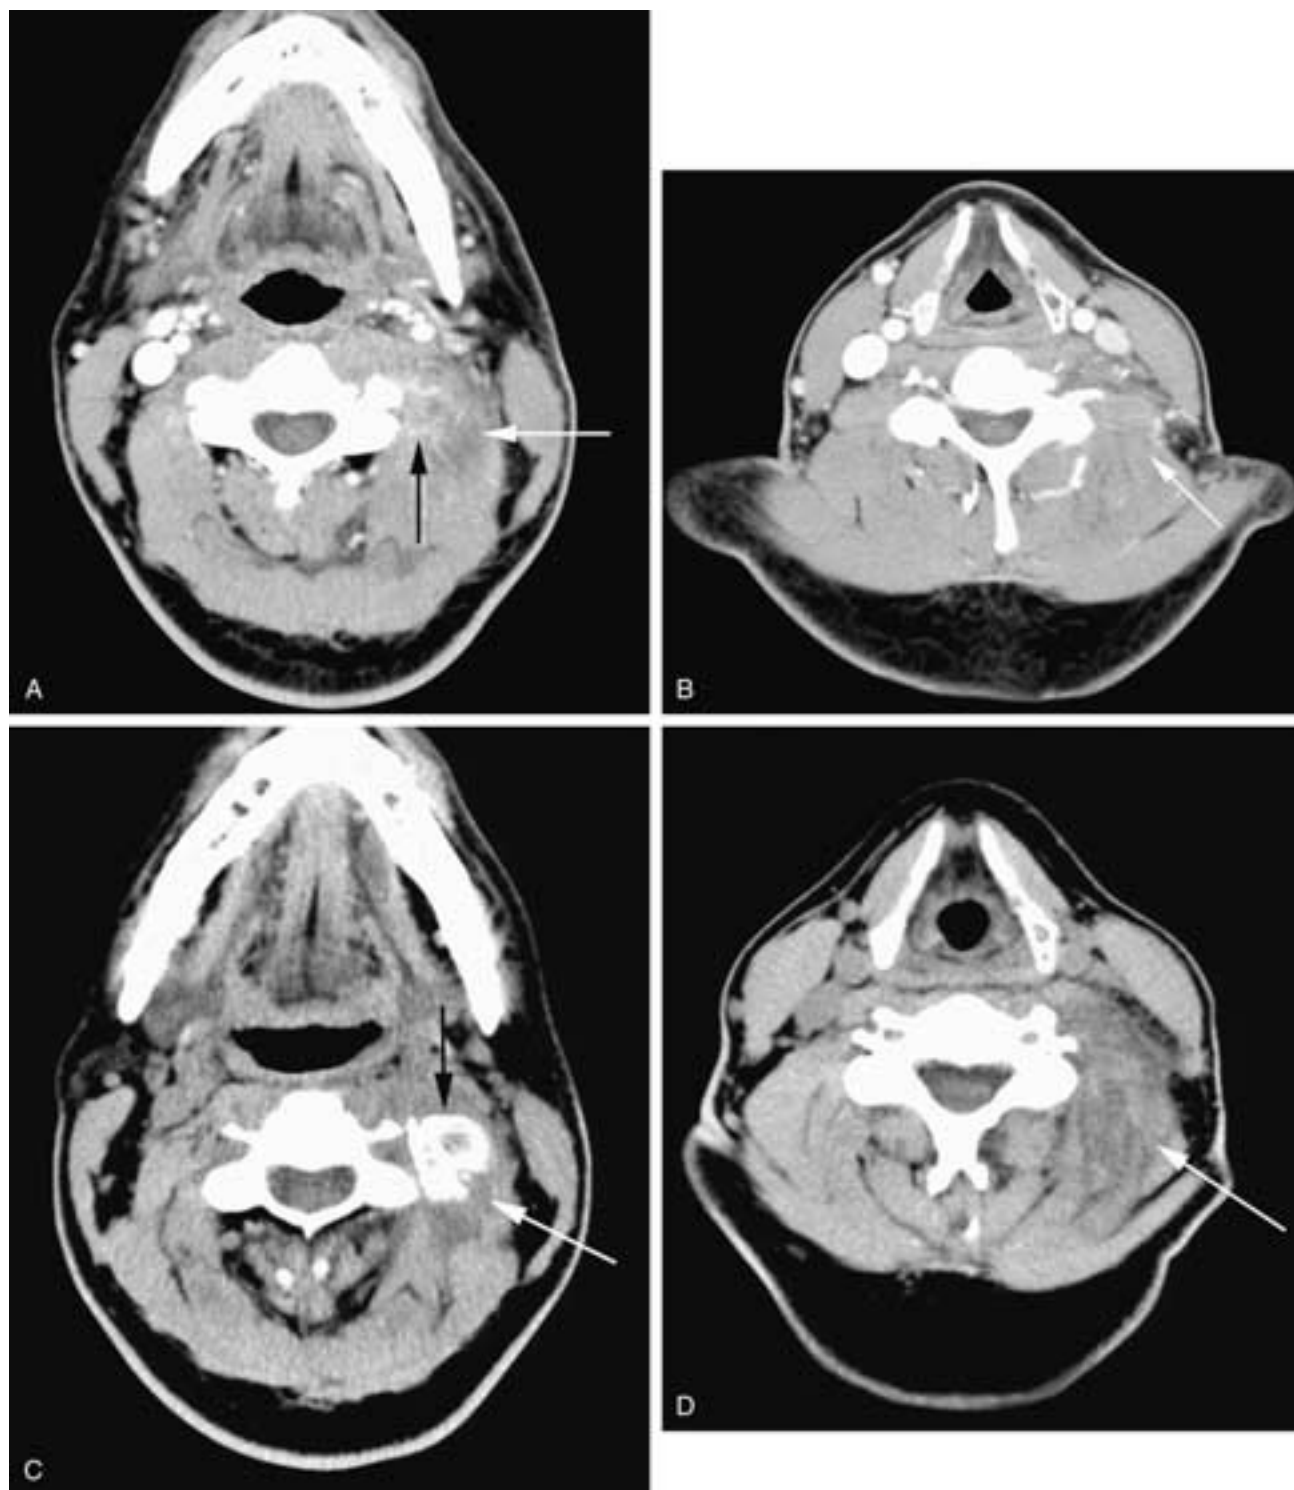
Axial contrast-enhanced CT scans (A and B) of the neck obtained 1 week after a 38-year-old male complained of neck pain. In A, there is a vague area of low attenuation and fullness in the left paraspinal muscles (*white arrow*), and there is a faint curvilinear density (*black arrow*) that could be interpreted as enhancement within the mass. A more caudal scan (B) shows a vague low attenuation and fullness in the left paraspinal muscles (*arrow*). Unenhanced CT scans (C and D) obtained 1 month after onset show that in C there is now a well-defined calcified/ossified density (*black arrow*) within the enlarged, otherwise low-attenuation (*white arrow*) left paraspinal muscles. This radiodensity corresponds to the area that may have been attributed to enhancement on the prior study (A). In D, there is enlargement and low attenuation in the left paraspinal muscles (*arrow*).
